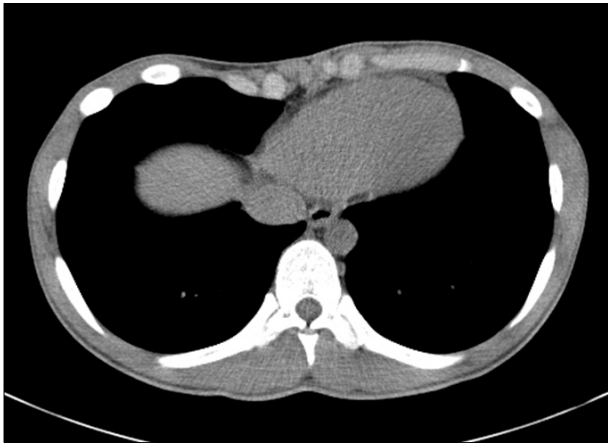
Preoperative chest computed tomography scan shows that the right chest wall is concave compared to the left chest wall.
